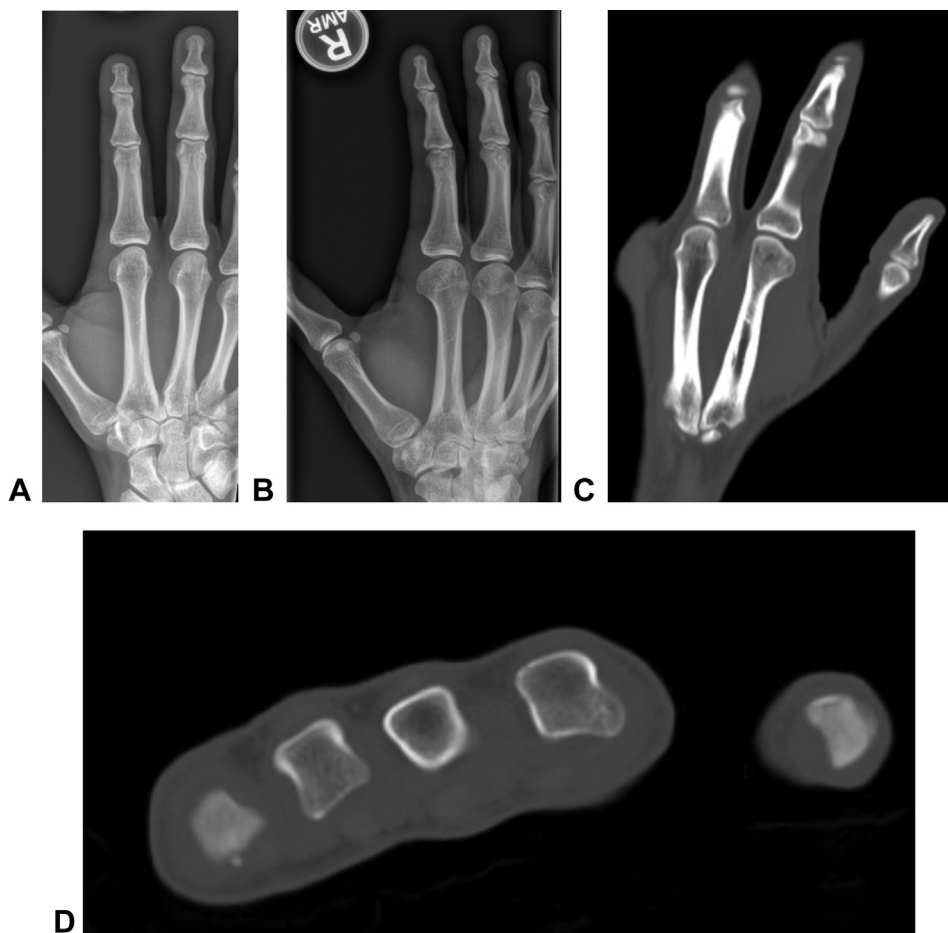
A and B Preoperative posteroanterior and oblique radiographs. C and D coronal and axial computed tomography scans demonstrating 8 × 7 × 10 mm osseous mass projecting from the radial aspect of the index metacarpal neck.
